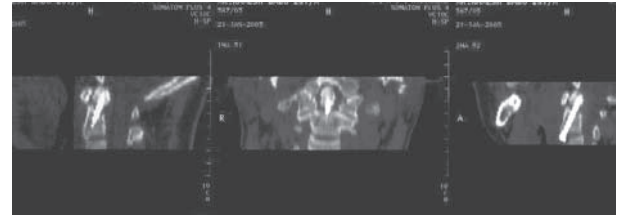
2D reconstructed CT images of Type II odontoid fracture, managed with Anterior odontoid screw placement.
